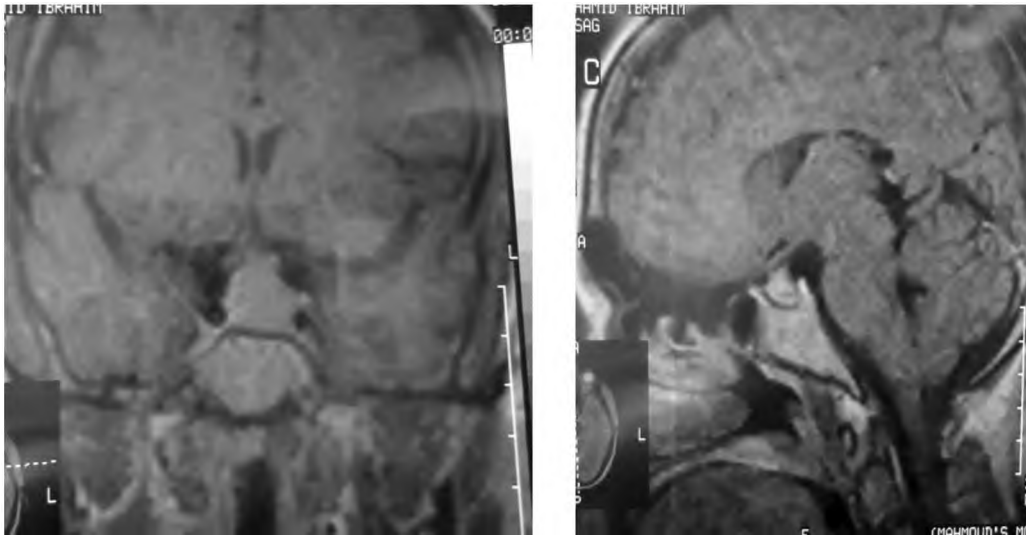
Preoperative MRI sella with contrast. Left, coronal view. Right, sagittal view.
